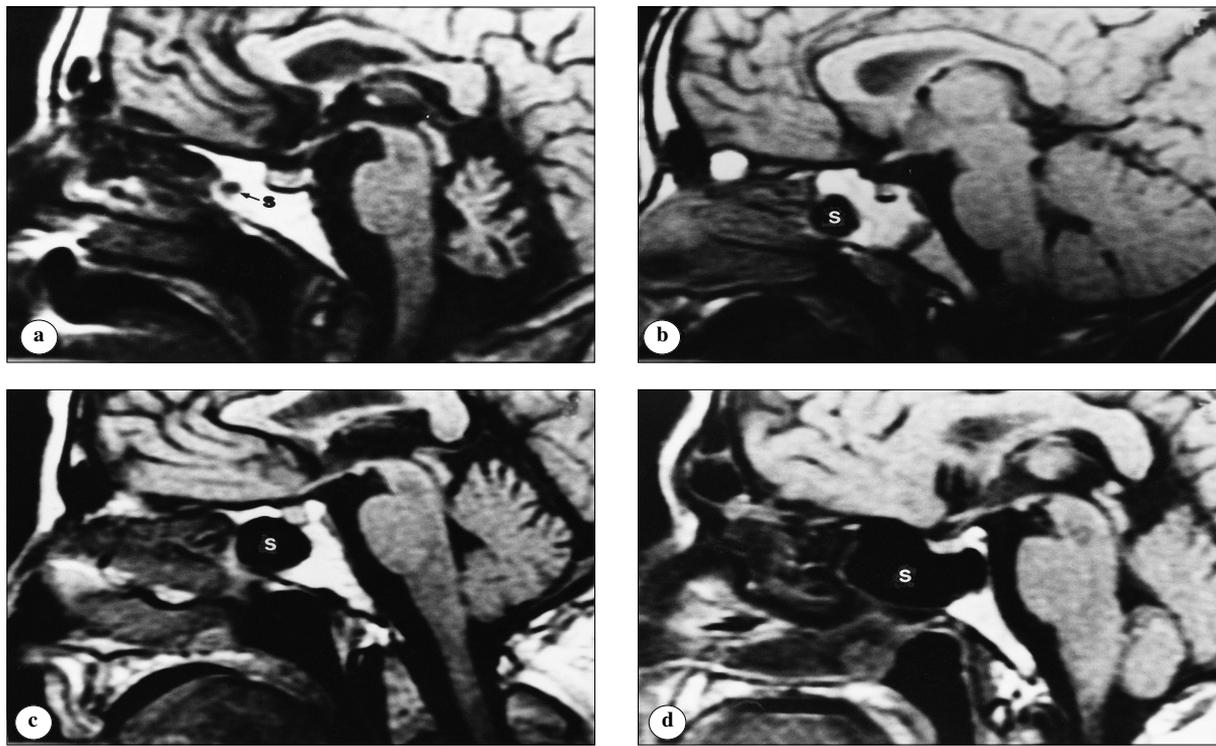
Sphenoid sinus pneumatization in MR images. a) conchal type. b) pre-sellar type. c) sellar type. d) post-sellar type. S - sphenoid sinus.
